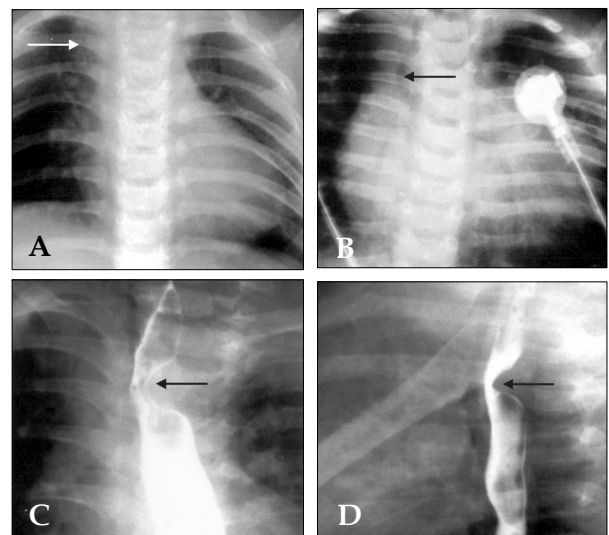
Plain chest radiographs showed a bulged contour (arrow) at the right upper cardiac border of a 4.5-month-old male (A), and deviations (arrow) of the trachea in a 16-day-old male (B). Barium esophagograms taken from a 4.5-month-old male showed an indentation (arrow) at the upper third portion of the esophagus, which is located on the left aspect of the frontal projection (C), and the posterior aspect of the lateral projection (D), respectively.
